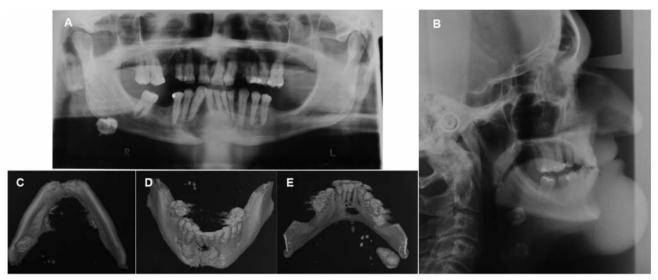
Radiographs of ameloblastic carcinoma. Panoramic (A) and lateral cephalometric (B) radiographs show a large radiolucent lesion in the anterior mandible causing displacement of the lower incisors. C-E: Computerized tomographic 3D reconstructions show extensive destruction of the mandibular base, and vestibular and lingual cortical bone.
